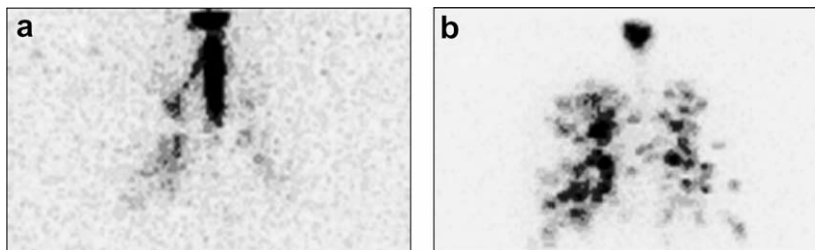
Gamma scintigraphic image showing micronized SBS (a) and nano-SBS (b).
